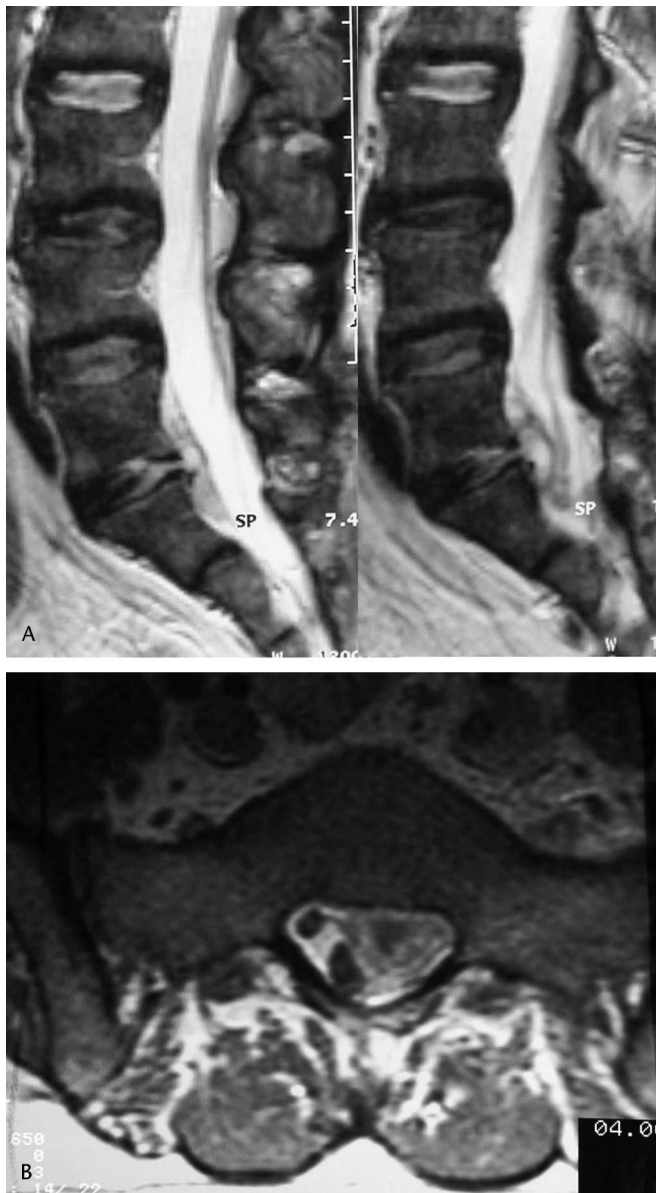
(A) A T2-weighted sagittal MRI shows an infected disc herniation. (B) A T1-weighted axial MRI shows an epidural abscess.
